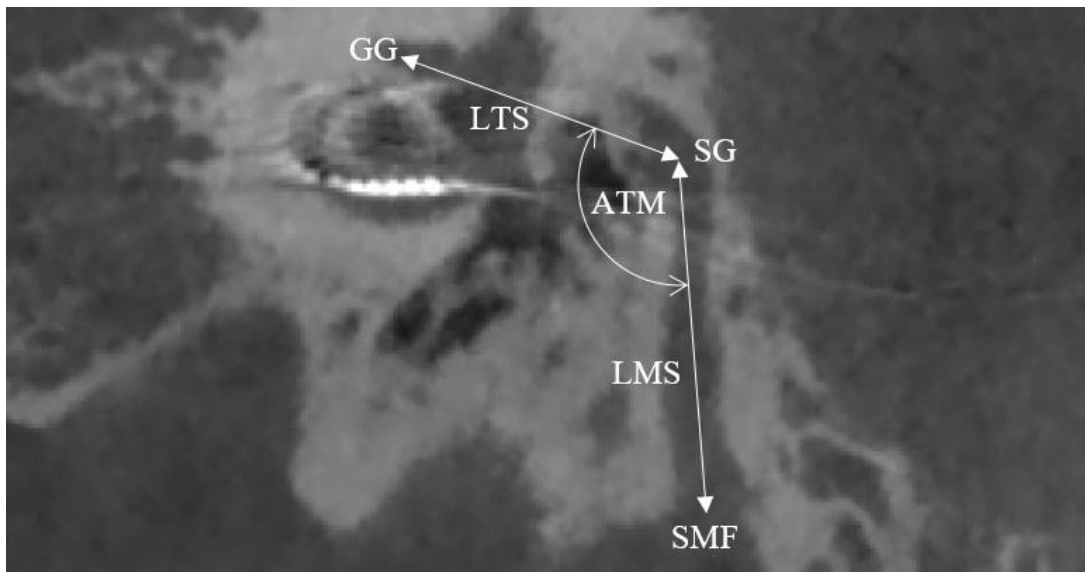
CT scan indicating the way in which the LTS, LMS and ATM were measured.
